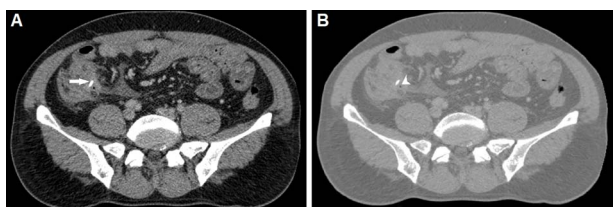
Abdominal CT scanner showed a high-density FB intra-cecum (A, arrow), with fat stranding around the cecum. Foci of gas extra-cecum and near the FB were also observed (B, arrowhead).
